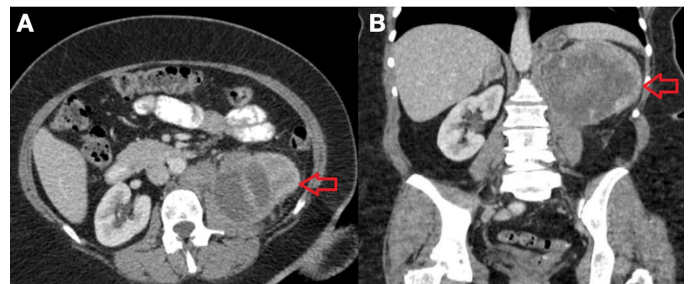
Enhanced computed tomography slides of the renal mass. A) Arrow show the left kidney mass in axial slide, B) Arrow show the mass in coronal slide
